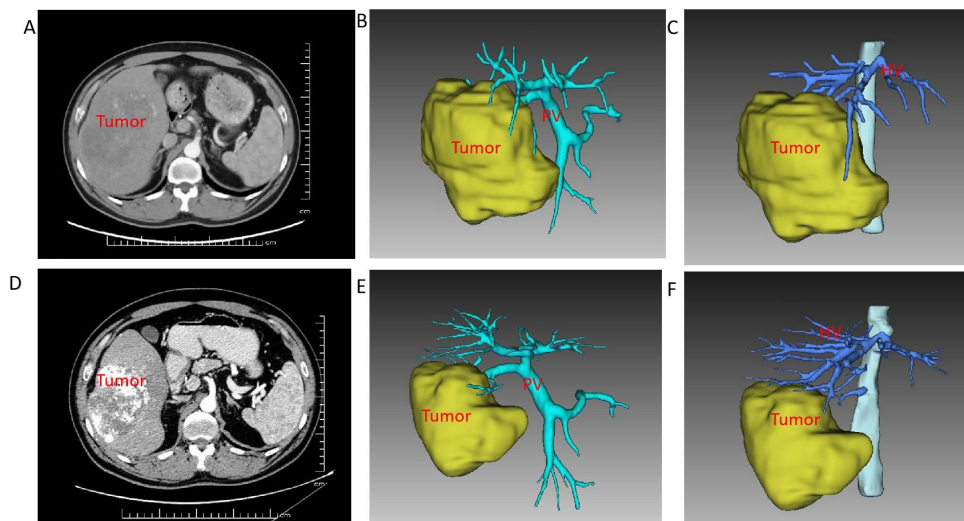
CT findings at the initial visit showed obvious enhancement in the arterial phase of the tumor, and the 3D reconstruction showed that the tumor invaded the end of the right anterior branch and the right posterior branch of the portal vein (A, B, C); CT findings and 3D reconstruction after conversion therapy showed lipiodol deposition in the tumor, weakened tumor enhancement and reduced volume (D, E, F).
